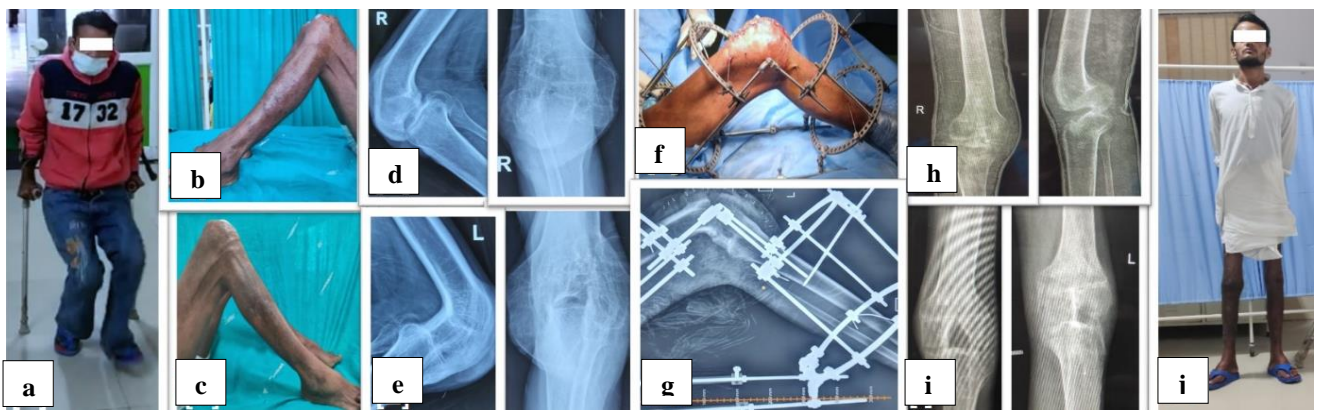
Representative images of case 1: (a) clinical image at presentation showing crouch gait with bilateral crutch support; (b) and (c) gross wasting bilateral lower limbs of muscles with the gross bilateral fixed flexed knee of 80 degrees on the right and 90 degrees on left; (d) and (e) plain radiographs showing bilateral fixed flexed knee, with gross bony ankyloses; (f) intra-operative image of left lower limb after deformity correction by anterior wedge osteotomy and knee spanning hinged-based Ilizarov fixator application; (g) post-operative radiographs showing Ilizarov fixator in place where distraction started according to the law of a similar triangle; (h) and (i) radiographs at final follow-up showing extended knee with stable bony fusion; and (j) clinical image at final follow-up, where patient could stand without support and walk on his own with an extended knee with the support of walking aids.
